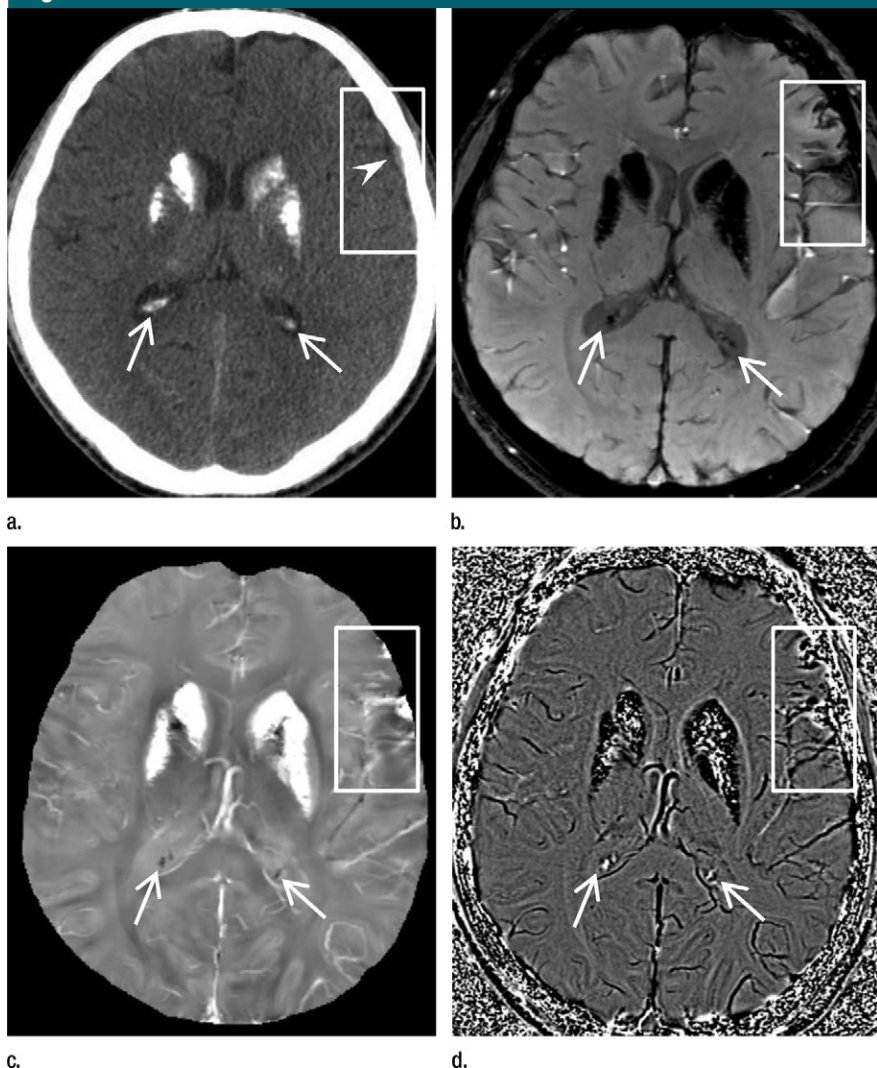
Calcifications (arrows) and hemorrhages (box) in 42-year-old man with hypoparathyroidism and 2-week-old traumatic brain injury. (a) CT scan shows hyperattenuating calcifications in bilateral basal ganglia and choroid plexus and hyperattenuating hemorrhage (arrowhead) in left frontotemporal lobe. The choroid plexus calcifications are considered physiologic. (b) T2*-weighted MR image shows calcifications and hemorrhages indistinctly with hypointense appearances. (c) QSM image shows basal ganglia as primarily paramagnetic (hyperintensity mixed with hypo- and/or isointensities), the hemorrhage as paramagnetic, and the choroid plexus calcifications as diamagnetic. (d) GRE phase image shows calcifications and hemorrhages indistinctly with heterogeneous appearances, causing one reader to misclassify hemorrhage as calcification.
